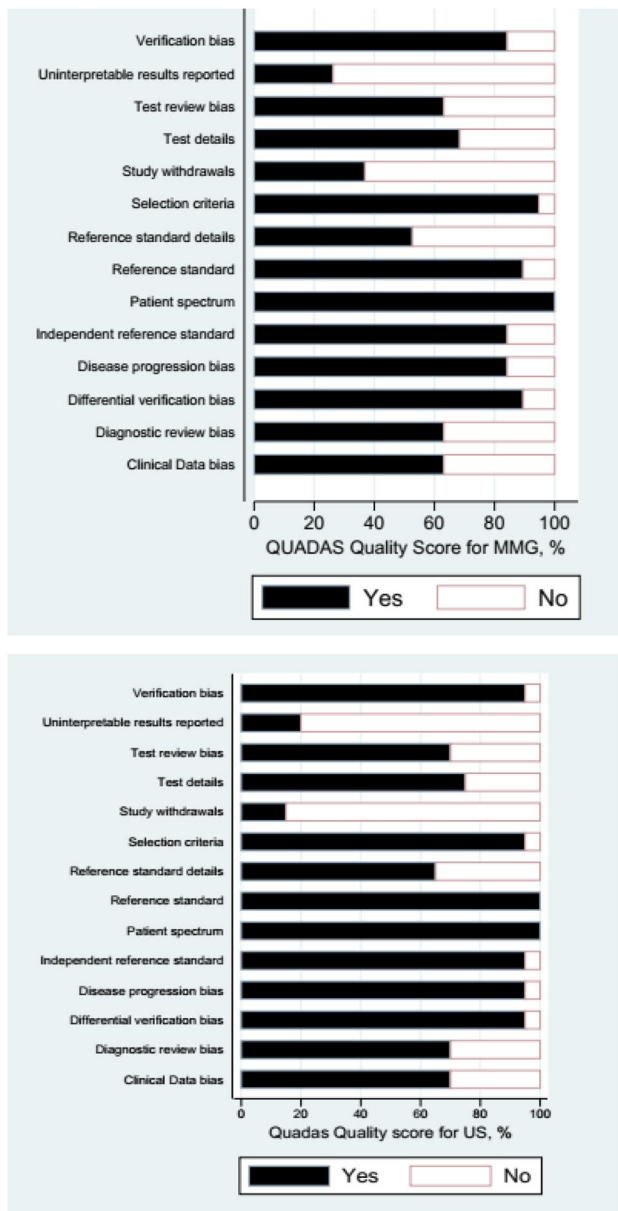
Quality score for mammography and ultrasound imaging modalities
